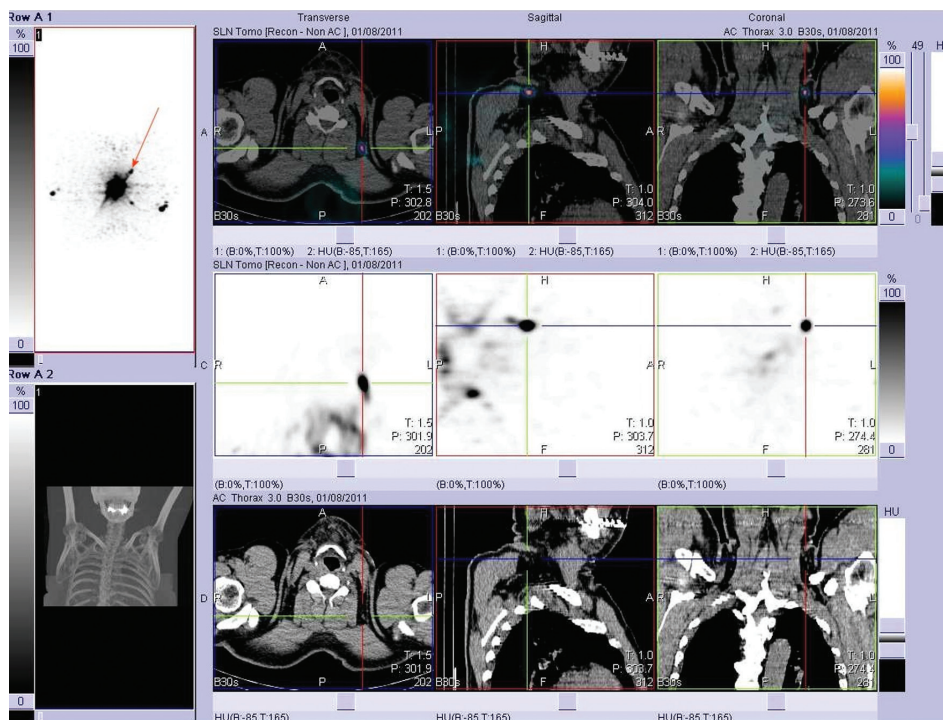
The same patient as in the figure 3 and 4. Fusion of SPECT and CT. Exact localization of SLN on the left side of the neck
